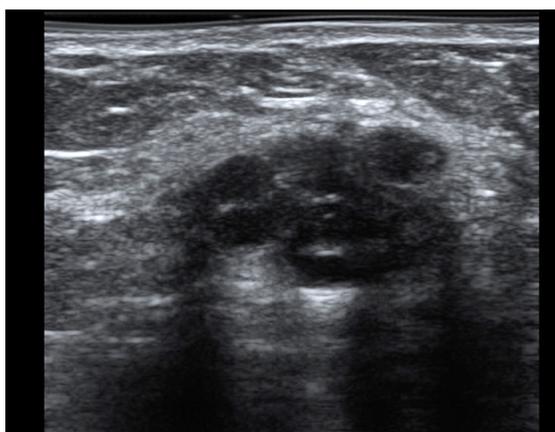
Transverse sonogram of the abdominal wall showing a nodule with hypoechoic content and cystic images
